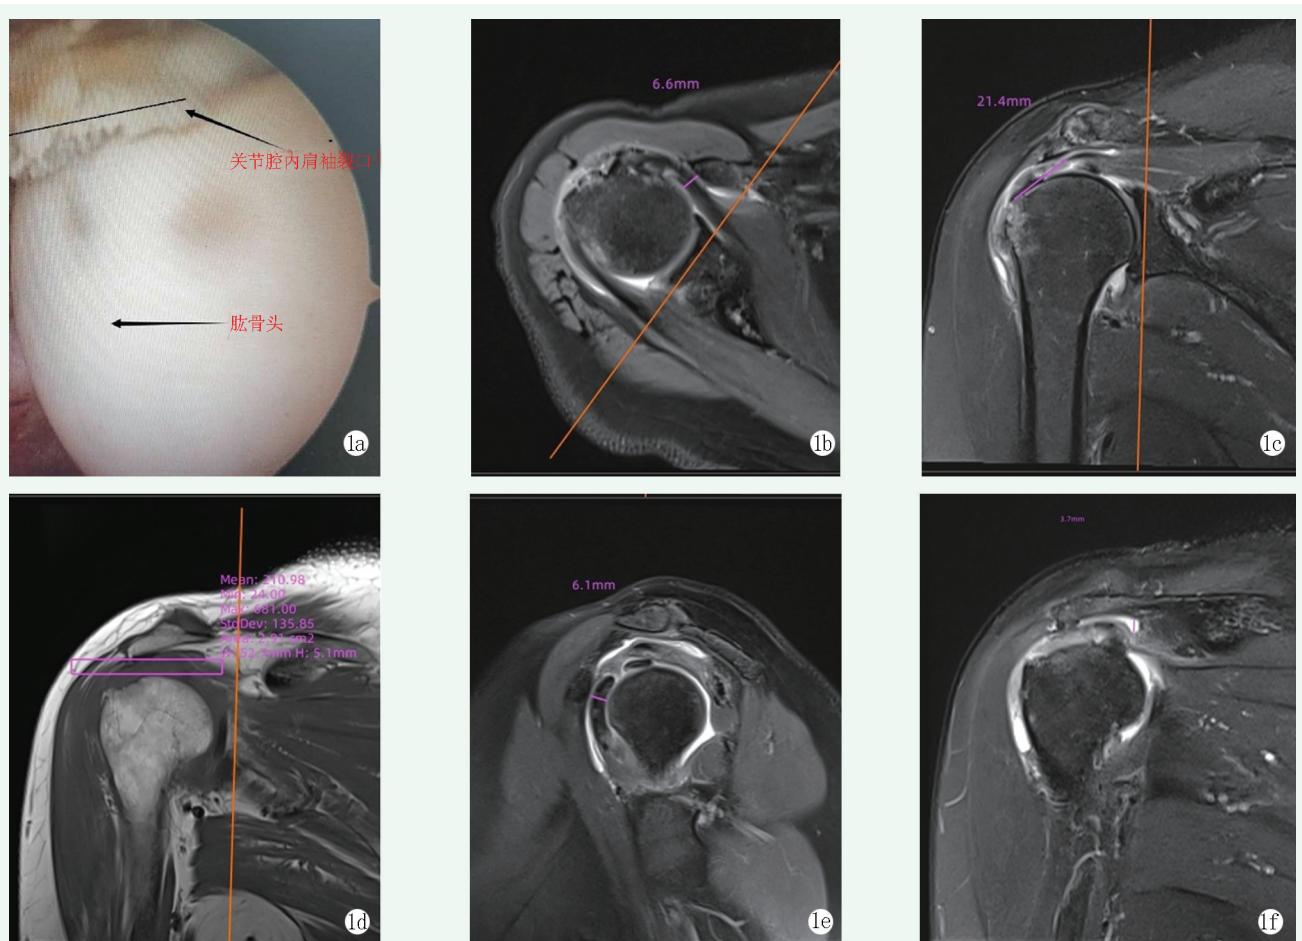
冈上肌腱撕裂手术及 MRI 评估。1a: 肩关节镜下显示冈上肌腱全层撕裂; 1b: 横断面喙肱距离; 1c: 冠状面冈上肌腱撕裂长度; 1d: 肩峰肱骨间距; 1e: 斜矢状面喙肱距离; 1f: 肩峰下积液厚度。
